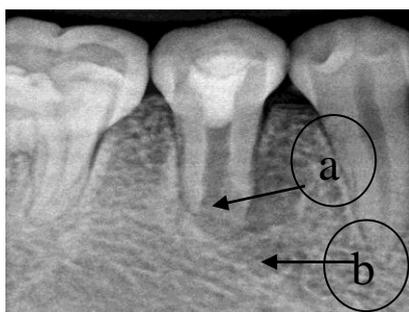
6 month post-operative view of 45 indicating little radiopacity in relation to root apex indicating hard tissue generation(a) and partial resolution of periapical lesion in relation to the tooth (b).
